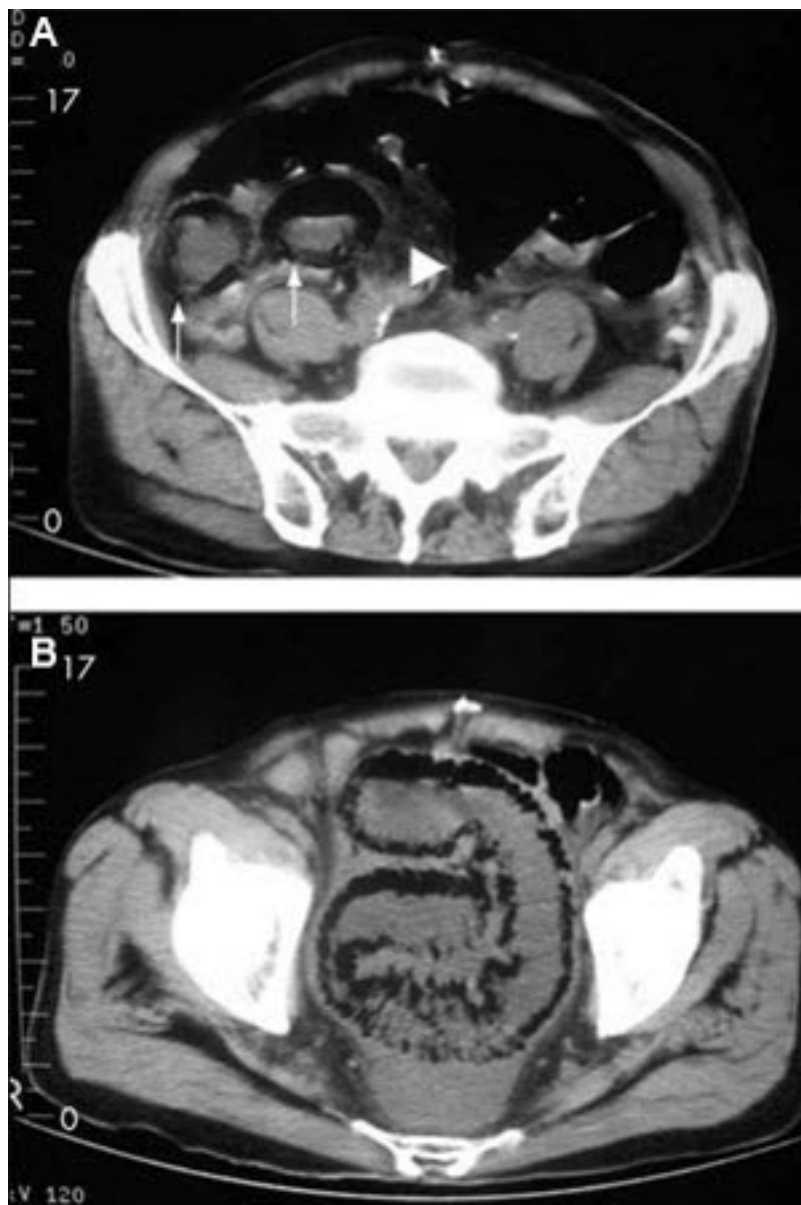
Ischaemic bowel disease: 84-year-old man presenting with symptoms suggestive of ischaemic bowel disease: (A) Abdominal CT revealing a massive circumferential and band-like air formation as intestinal pneumatosis (arrows) and pronounced edema of mesenteric fat (arrowhead) around necrotic bowel loops; (B) Another slice of abdominal CT showing long segmental pneumatosis of the small bowel
